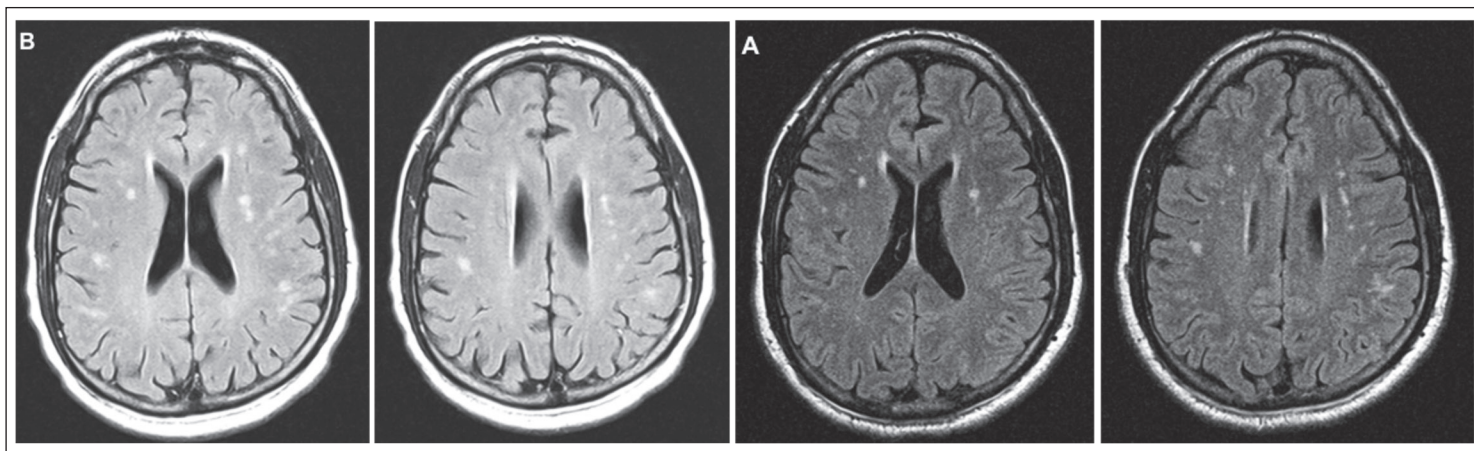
(A) T2-fluid-attenuated, inversion recovery (FLAIR) sequence for AB showing multiple somewhat discrete T2 hyperintensities located primarily in the deep white matter. (B) Comparison T2-FLAIR sequence from scan performed three years prior to initial clinical visit showing stable appearance of T2 abnormalities.
